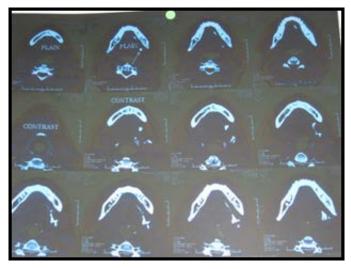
CT Scan showing submandibular salivary stone
